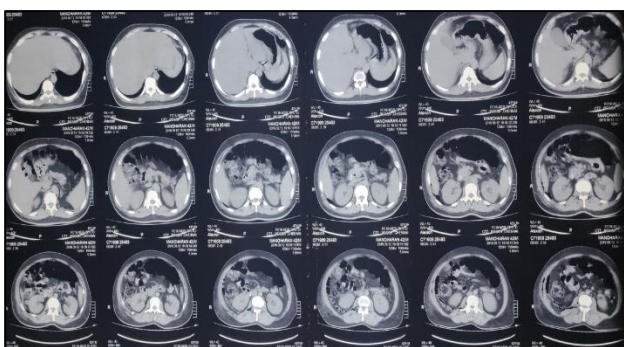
CT abdomen upper cut section showing air in the extraperitoneal space.
